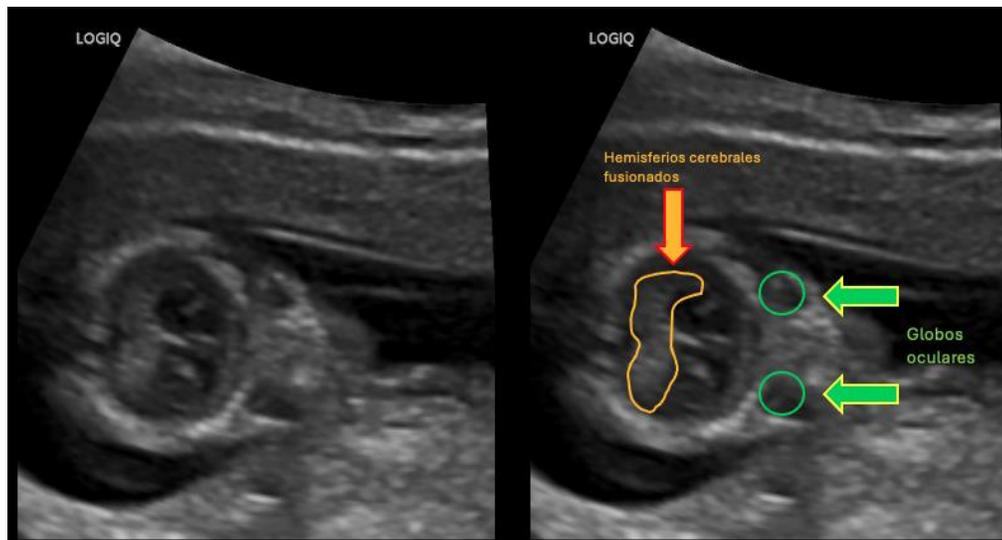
Fetal ultrasound. Coronal section at the supraorbital level.
